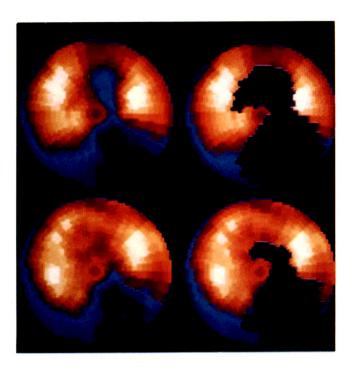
201 TI-SPECT study in 56-year-old man with prior myocardial infarct who presented with recurrent angina pectoris.
